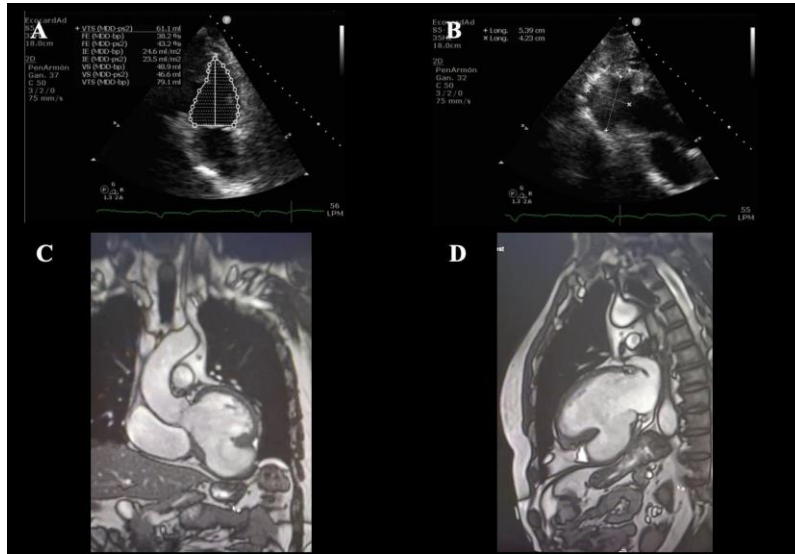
Echocardiogram: A) Ejection fraction of 38.2%. B) Aneurysm dimensions of 54 x 42 mm. MRI with aneurysm of the inferior and inferolateral wall of the left ventricle. C) Frontal section. D) Sagittal section.
